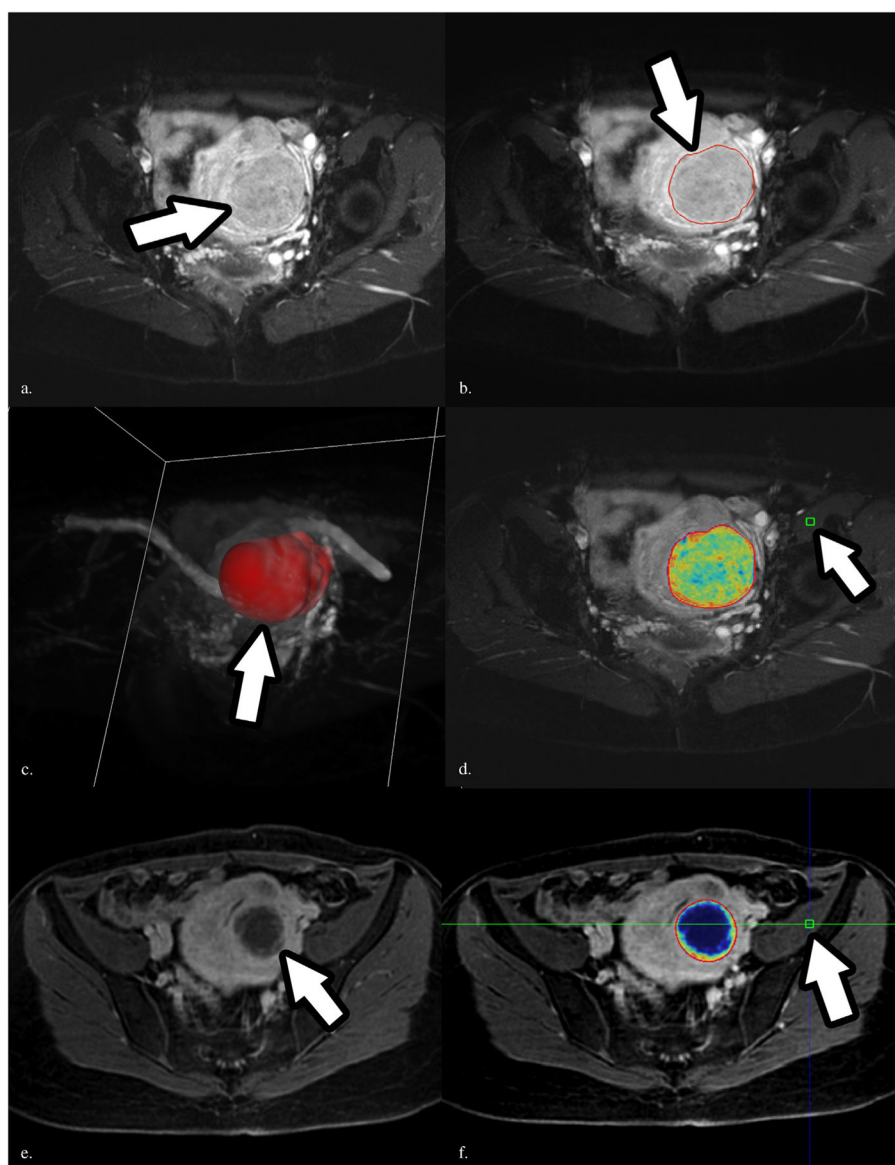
Software-assisted 3D quantification technique. (a) Representative contrast-enhanced MR imaging scan performed before the procedure. Arrow points to dominant fibroid lesion. (b) Semiautomated tumor segmentation, which includes the entire lesion on the scan performed before the procedure. Arrow indicates the rim of the segmented lesion. (c) Volume rendering for the segmented lesion in a maximum intensity projection on the scan performed before the procedure. Arrow indicates the lesion (in red). (d) Color map of the same lesion before UAE; the color coding varies from red representing maximum enhancement to blue representing no enhancement. Arrow indicates the ROI within the left psoas muscle, which was used as a reference. (e, f) Contrast-enhanced follow-up MR imaging scans from the same patient after UAE, with and without the color map overlay. Arrow in (e) indicates the centrally necrotic uterine fibroid. Arrow in (f) indicates the ROI, consistently placed within the left psoas muscle.
